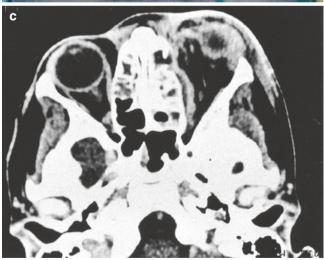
Subperiosteal abscess in orbital cellulitis. (a) Photograph in primary gaze demonstrating edema, erythema, and proptosis. (b) Photograph in upgaze demonstrating limitation of ocular motility in the left eye. (c) CT scan of this patient with ethmoidal sinusitis, a medial subperiosteal abscess, and orbital cellulitis
